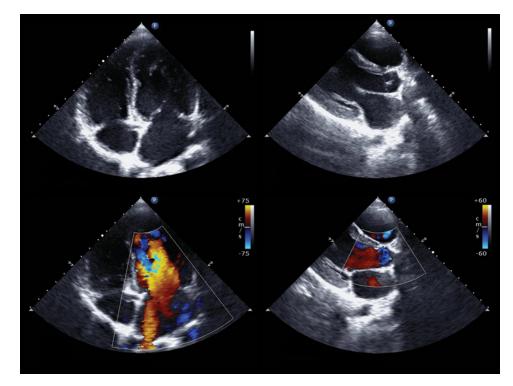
Echocardiogram with and without Doppler. © kalewa/Shutterstock.
